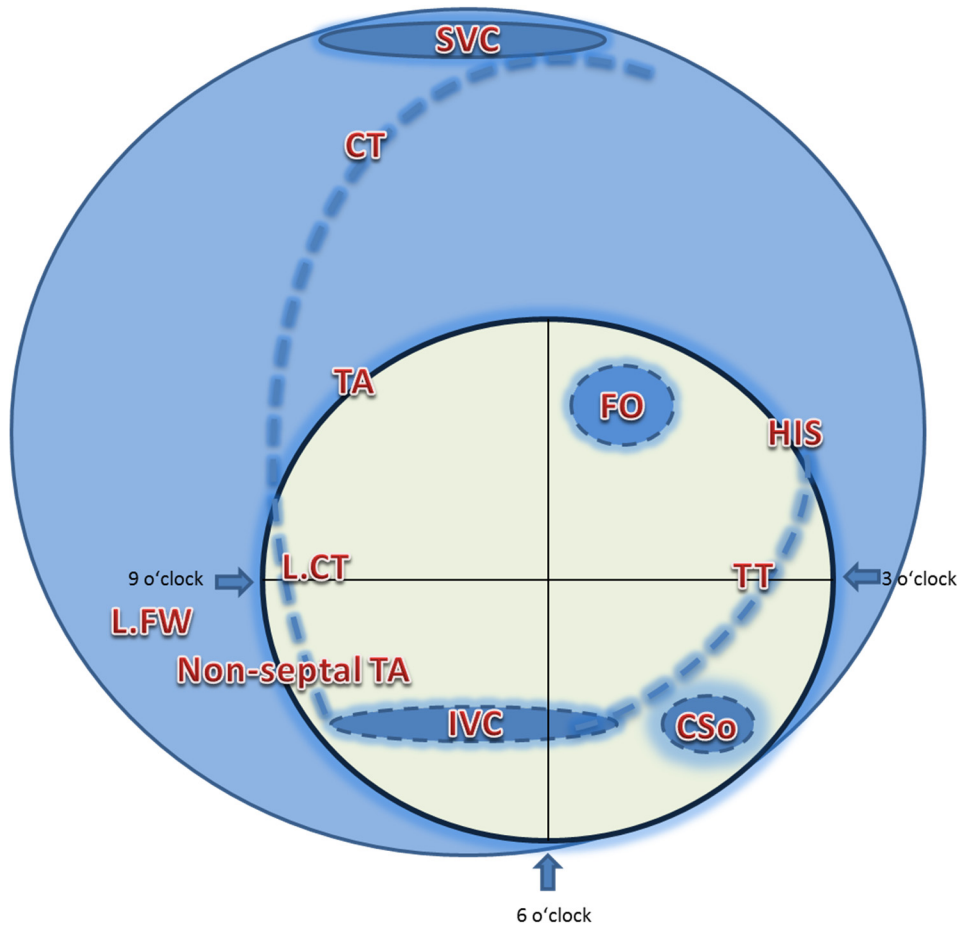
Localization of anatomical structures in the lower right atrium. SVC: superior vena cava. TA: tricuspid annulus. CT: crista terminalis. FO: fossa ovalis. L.FW: lower free wall. L.CT: lower crista terminalis. TT: Tendon of Tudaro. CSo: coronary sinus ostium.
